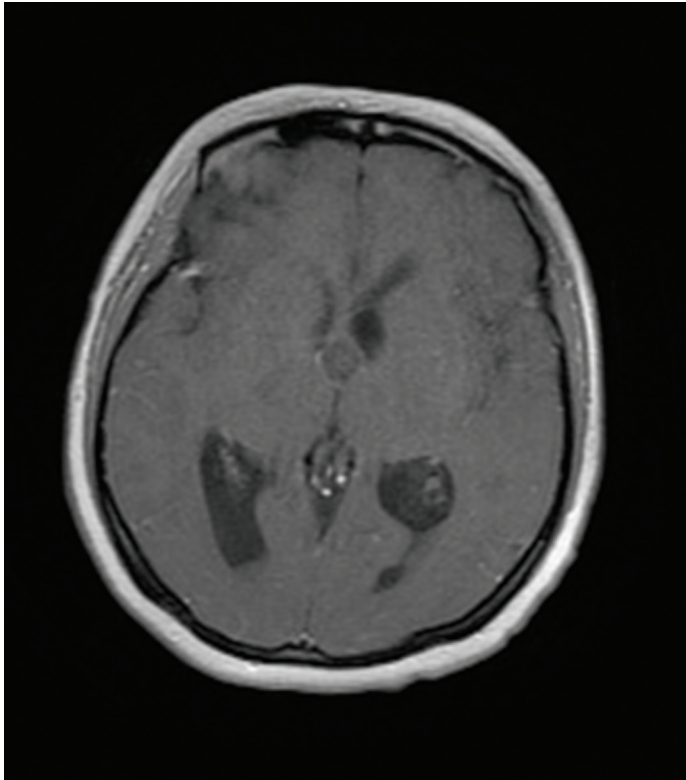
Preop contrasted T1A axial section MRI.
